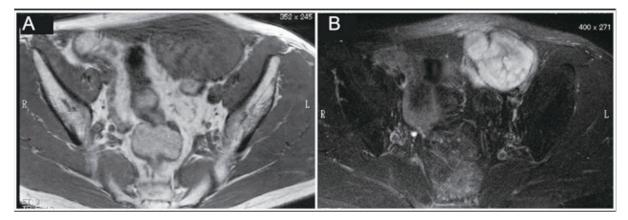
Abdominal magnetic resonance imaging. A: T1-weighted image showing low signal intensity associated with a lobulated mass. B: T2-weighted image showing inhomogeneous high signal intensity.
